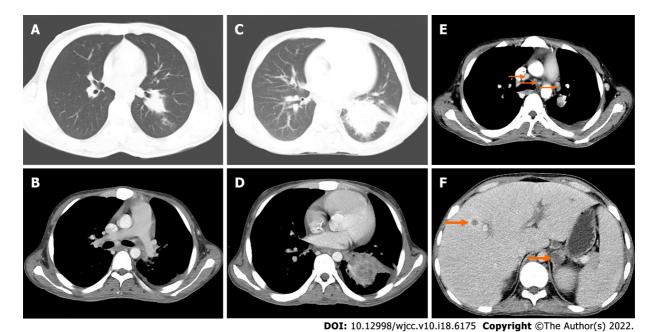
Computed tomography 43 mo (A-B) and 50 mo (C-F) after surgery. A: The nodule of the lower lobe of the left lung was obviously enlarged, and the boundary was not clear. The size was about 2.5 cm × 3.5 cm; B: The soft tissue nodule of the left pleura showed slight enhancement, with a small amount of fluid density in the left pleural cavity, C: The irregular mass in the lower lobe of the left lung was significantly larger than before, with a size of about 8.2 cm × 5.7 cm; D: After enhancement, the focus showed moderate enhancement; E: Multiple enlarged lymph nodes in mediastinum, left hilum and left axilla; F: Low-density soft tissue mass of the left adrenal gland with unclear boundary and moderate circular enhancement.
